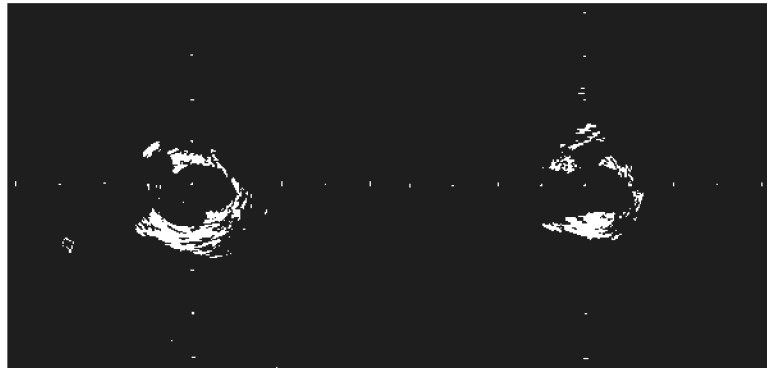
Intravascular ultrasound scan image shows axial collaterals surrounding postthrombotic stenotic vein.
